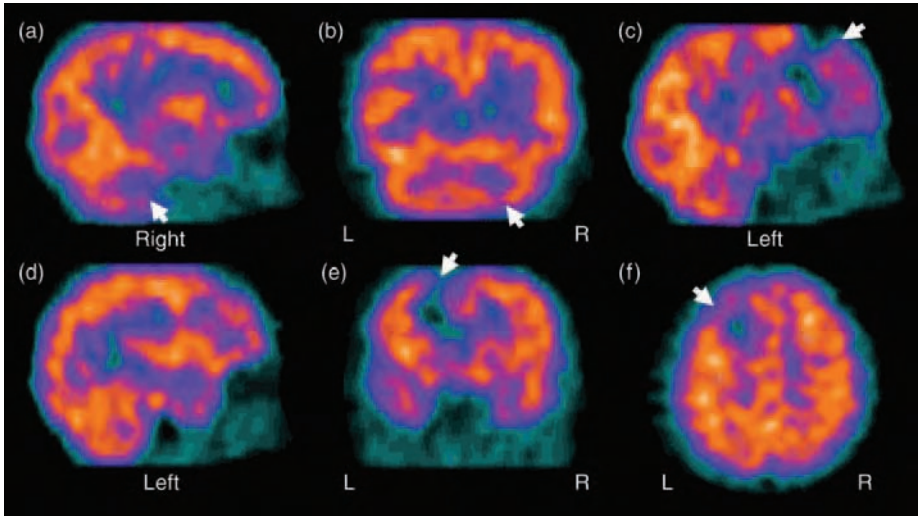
Single photon emission computed tomography (SPECT) imaging done the same day as the magnetic resonance imaging (MRI) in the child and case presented in Figure 19.4. The so-called 'warm colors' (orange and red) depict areas of normal radiotracer perfusion, whereas 'cool colors' (blues to purple) show areas of decreased perfusion. Although the focal lesion is in the left frontal lobe, clearly demonstrated by absent activity where the focal, tubular lesion occurred (arrows in c, e, and f), a form of diaschisis occurs where the crossed frontocerebellar pathways are disrupted, resulting in a lowering of activity (arrow in a) in the contralateral cerebellar lobe from the loss of input from the left frontal region. Comparing the right and left sagittal views it is obvious that there is unequal perfusion in the cerebellum, with reduced activity seen on the right. Note also the extensive lowered perfusion in the left frontal region anterior to the lesion (arrow in c) even though as shown in Figure 19.4d, this region has normal signal on T1 weighted MRI.
